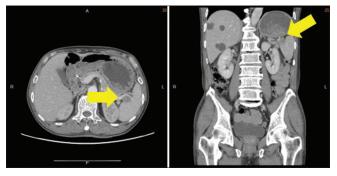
Abdominal computed tomography revealed wall thickening in the high body of the stomach with splenic invasion (yellow arrows)
